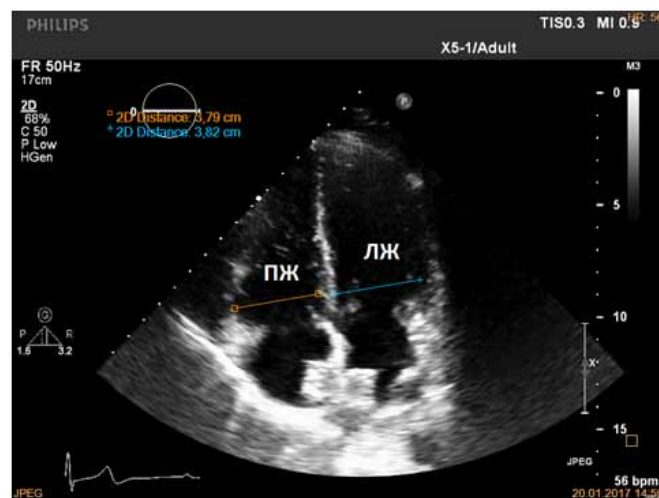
Apical four-chamber echocardiogram demonstrating basal diameters of the ventricles. RV / LV = 3.8 cm / 3.8 cm = 1 (N <1)
